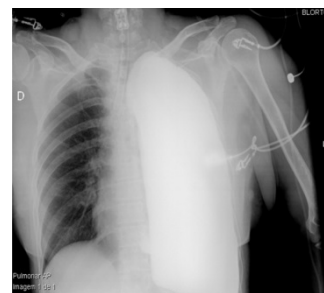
A thoracic x-ray
